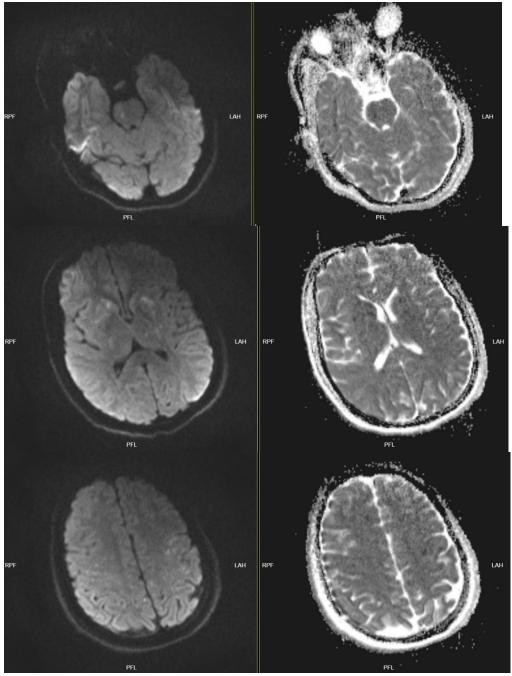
Multiple infarct areas on MRI
